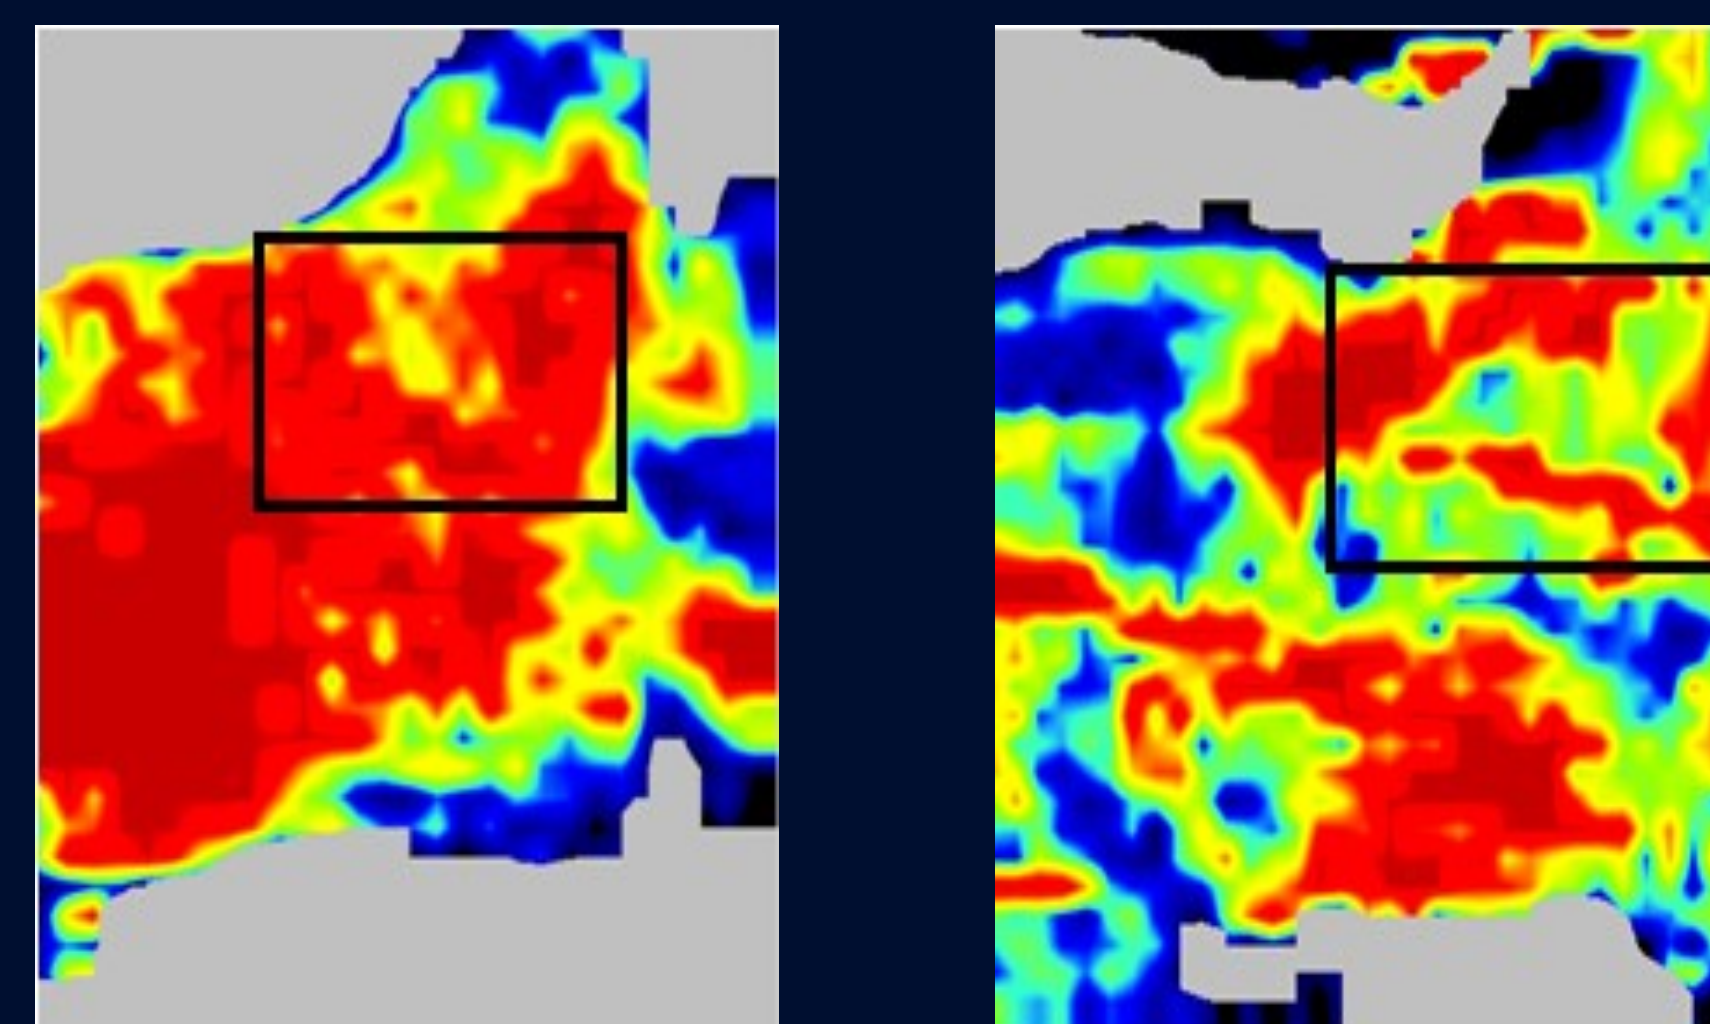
A pre-operative (left) and post-operative day 14 (right) Doppler image of a control subject. Note the ROI highlighted in black.
